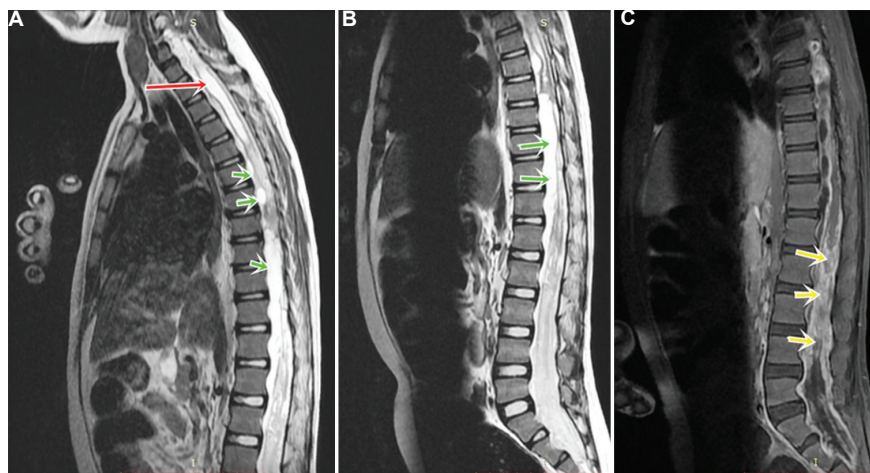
(A) Magnetic resonance imaging (MRI) cervicodorsal spine showing syrinx involving the cervical spine (red arrow) and cerebral spinal fluid loculations along the dorsal spine (green arrows). (B) MRI lumbo-sacral spine T2-weighted image showing cerebral spinal fluid loculations around lumbar spine (green arrows). (C) Post-contrast image showing enhancement and clumping of roots (yellow arrows).
